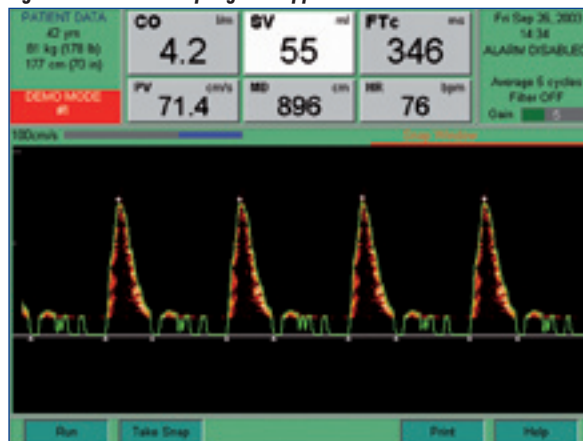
Normal oesophageal Doppler trace.
